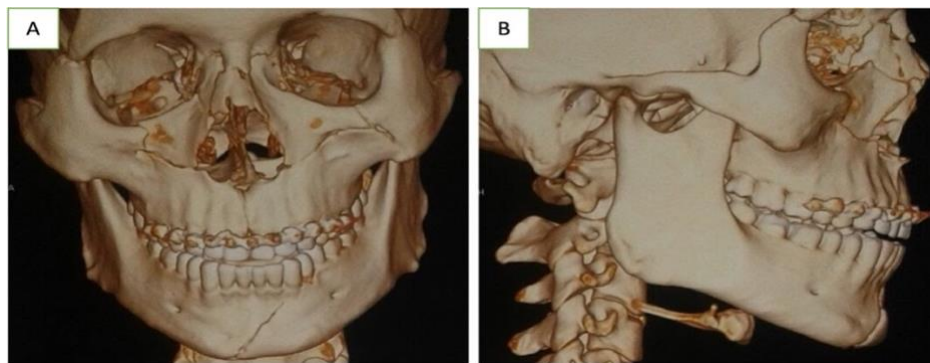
CT scan showing compound mandibular fracture in the para symphysis region, zygomatic fracture involving the orbital floor (A). No signs of fracture in the condyle and angle of the mandible
